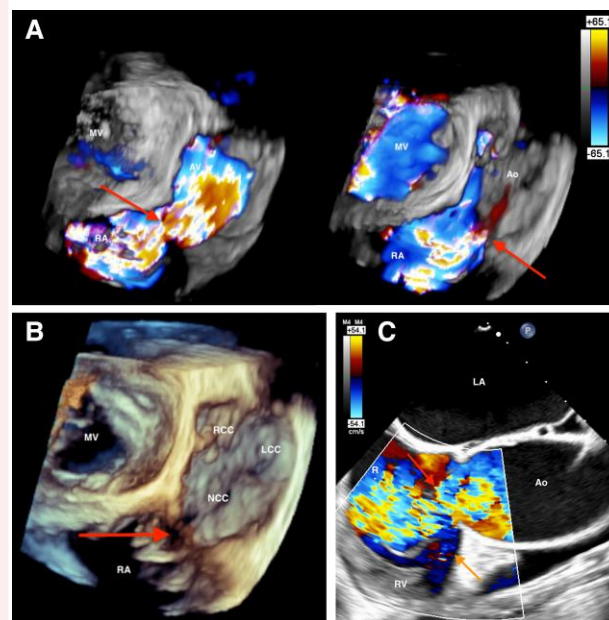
Transoesophageal 3D mid-oesophageal tilted enface left atrium view (A, B) demonstrating a ruptured sinus of Valsalva aneurysm with systolic (A, left) and diastolic (A, right) forward flow into the right atrium. Modified mid-oesophageal aortic valve short-axis view showing potential systolic flow apical to the septal tricuspid annulus concerning annular disruption (C, orange arrow). 3D, 3 dimensional.
